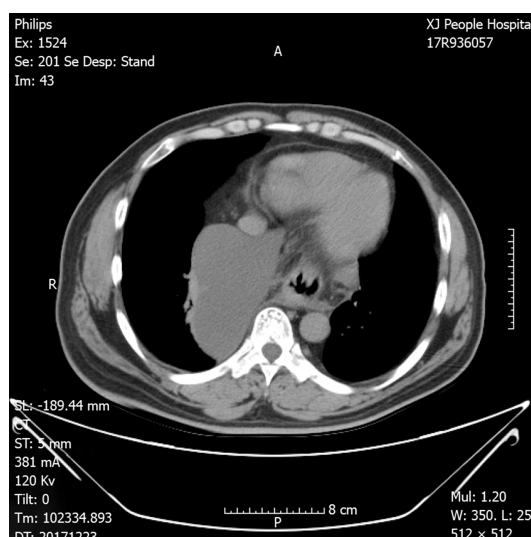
Chest computed tomography with volumetric analysis. Post-mediastinal location of the whole stomach along with peritoneal fat compressing both bilateral lung and heart.
